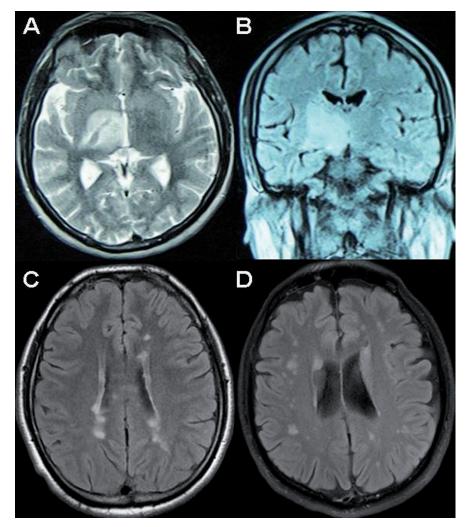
MRI sections of BD patients with abnormal neurological examination findings showing a typical parenchymal neuro-Behçet's disease lesion extending from diencephalon to basal ganglia (A, B), MS-like lesions (C) and non-specific lesions in the white matter (D).
